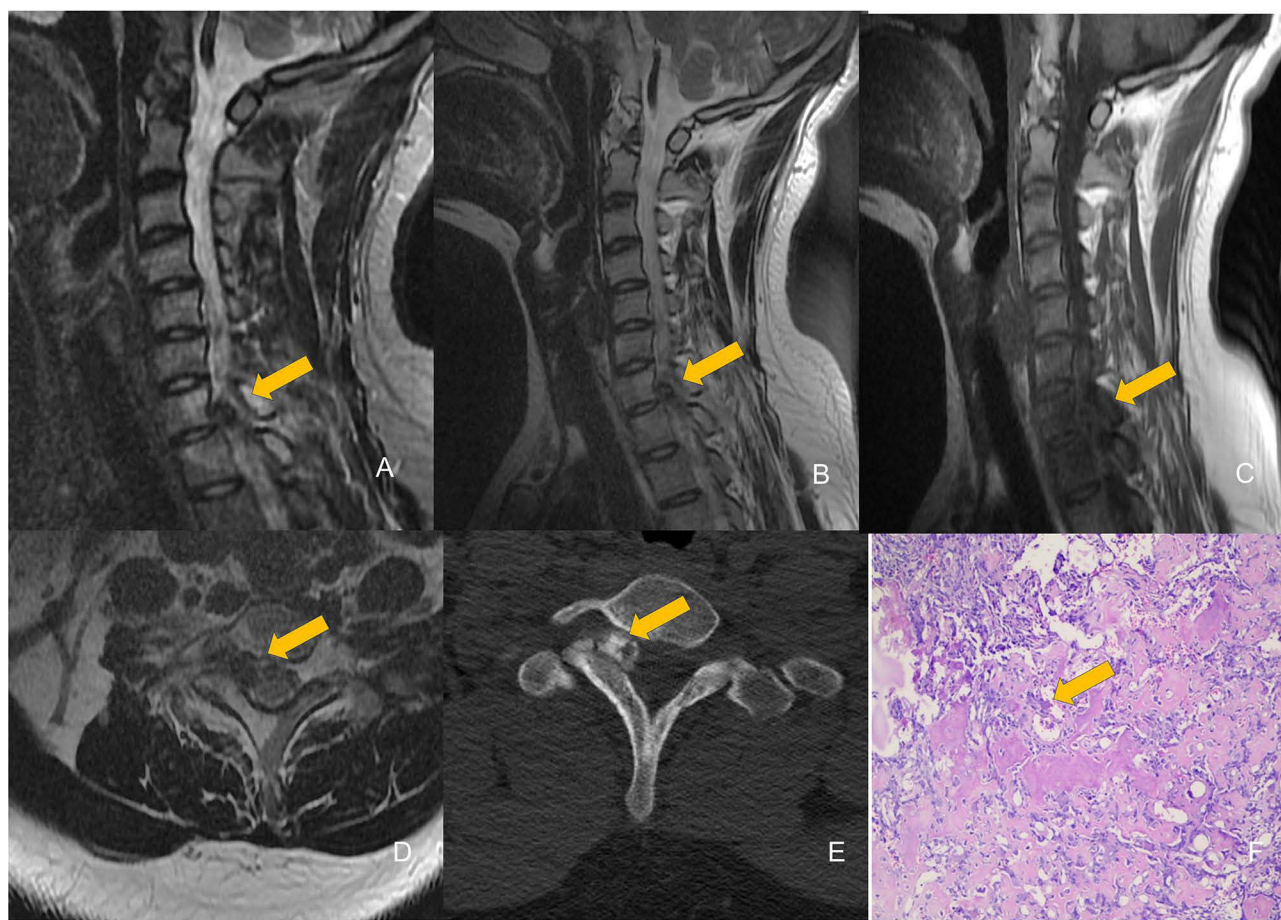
Osteoid osteoma of the Right Lamina of C7, Male, 18 years old, with right shoulder discomfort for over 1 year and worsening for over half a year. (A) Fat-suppressed T2WI sagittal view shows the lesion with low signal intensity, with extensive bone marrow edema visible around it. (B and D) T2WI sagittal and axial views show the lesion with low signal intensity. (C) T1WI sagittal view shows the lesion with low signal intensity. (E) CT plain scan reveals that the lesion is located in the right intervertebral foramen area, exhibiting heterogeneous and significant ossification, with no obvious invasion of the surrounding bone structures and no formation of a soft tissue mass. (F) HE ($\times 20$) shows that surfaces of the bone trabeculae are lined with osteoblasts and a small number of osteoclastic giant cells. Some of the osteoblasts (arrow) exhibit an epithelioid appearance with mild atypia.
